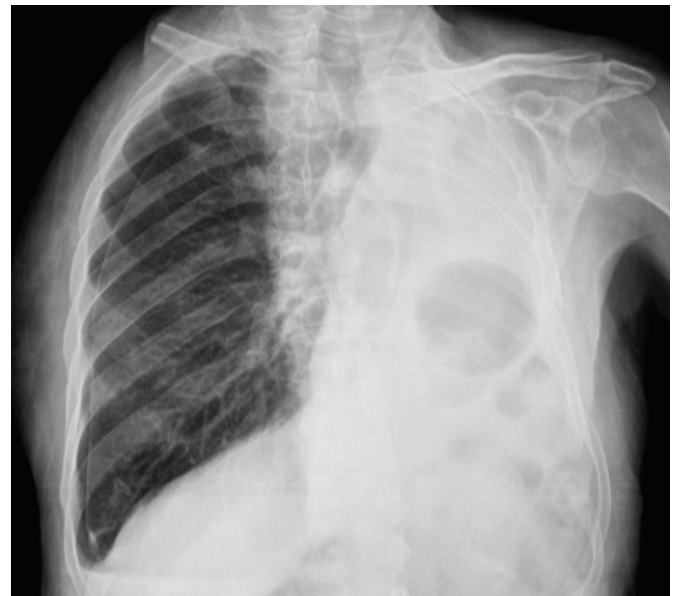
A chest X-ray demonstrated a right pneumothorax.
